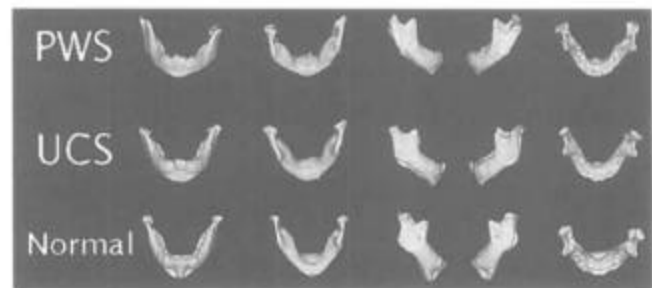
Typical 3-D CT osseous images of isolated mandibles from PWS, UCS, and normal patients. Asymmetry is overt in PWS, subtle in UCS, and negligible in normal images.
